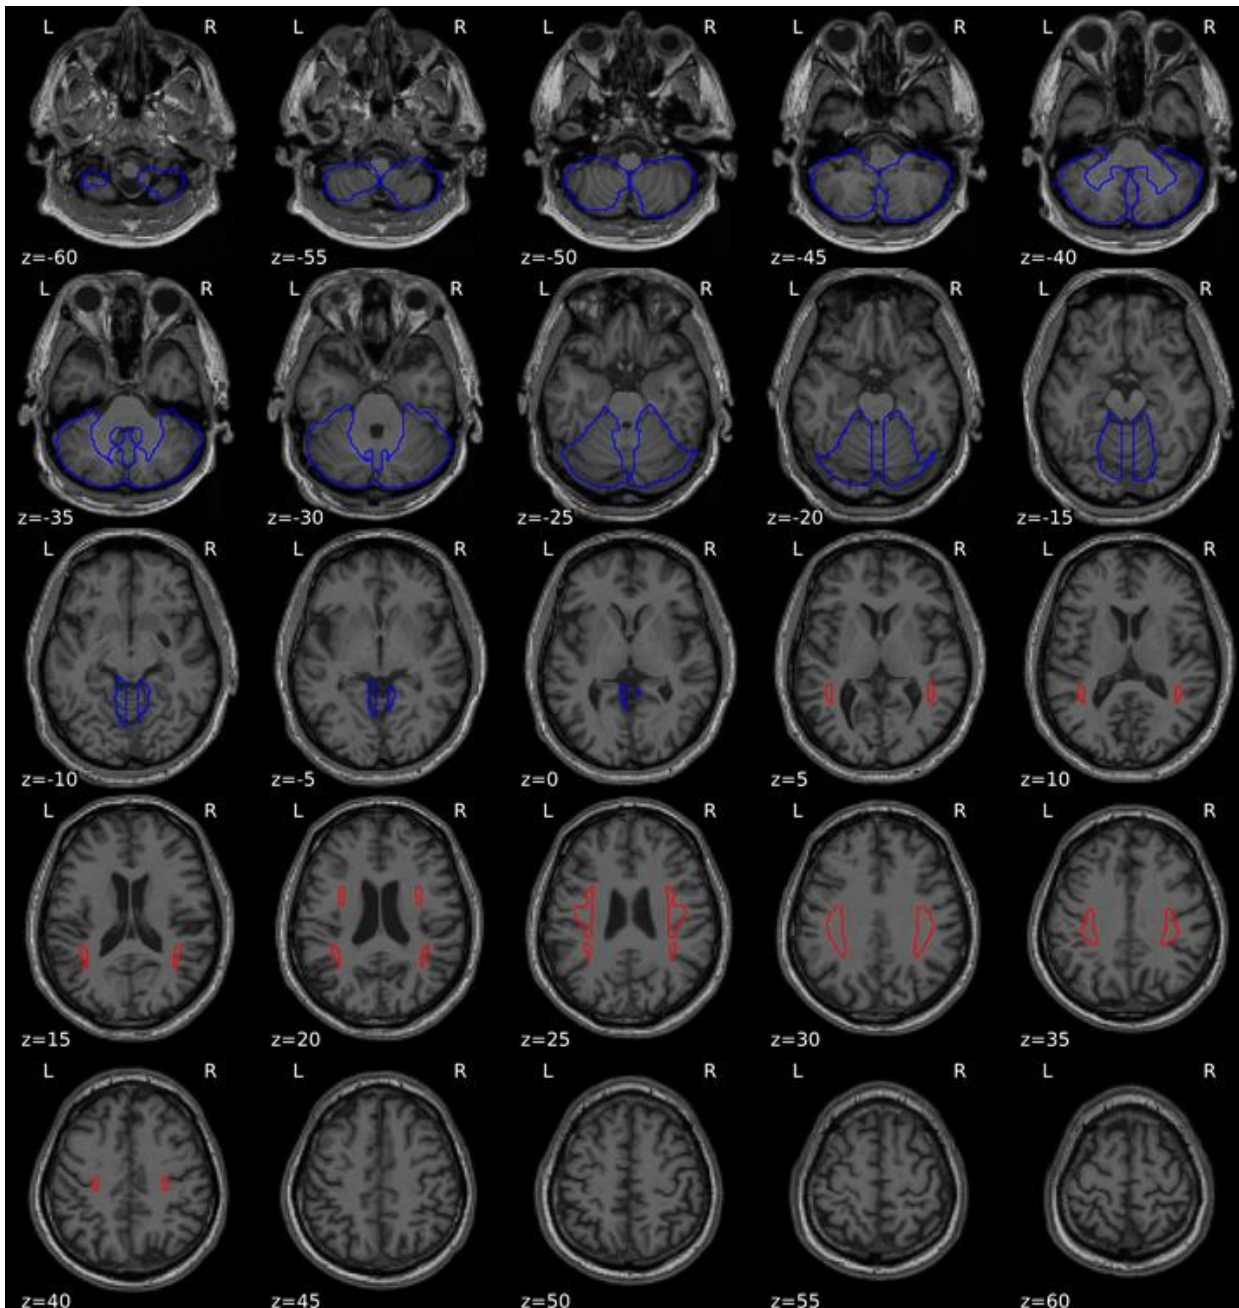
Example patient's normalized MRI with contours of cerebellum ROI (blue) and superior longitudinal fasciculus (SLF) ROI (red).
